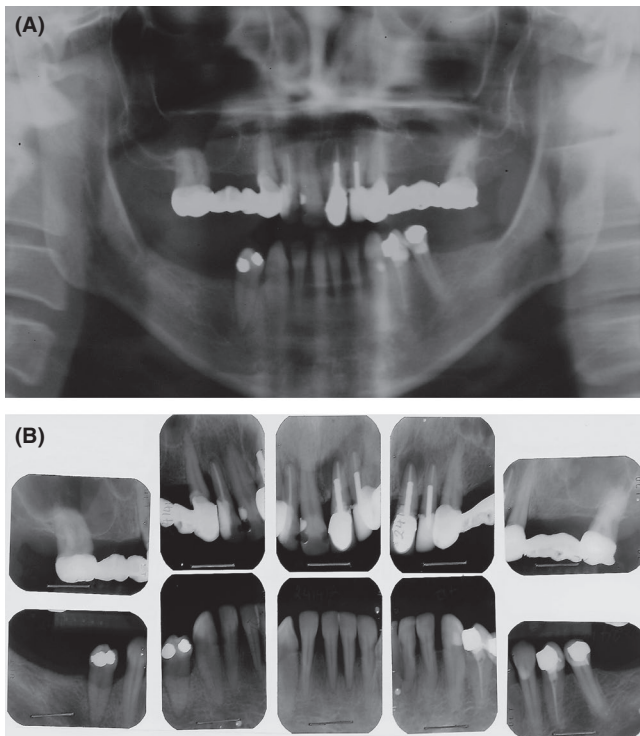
Preoperative radiographic evaluation. A, Preoperative orthopantomography. B, Preoperative intraoral periapical radiographs
